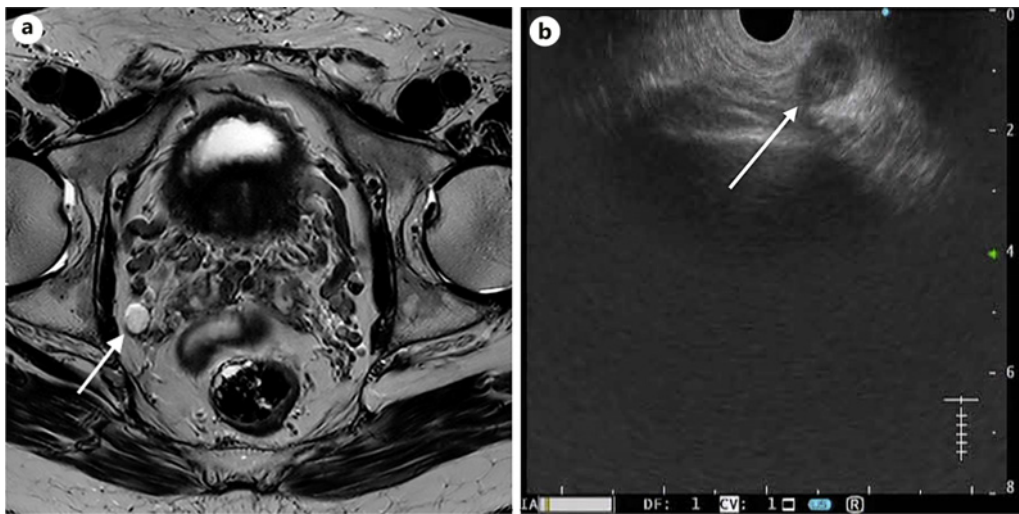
a, b MRI and EUS-FNA images of a suspected lymph node in the right obturator foramen.
